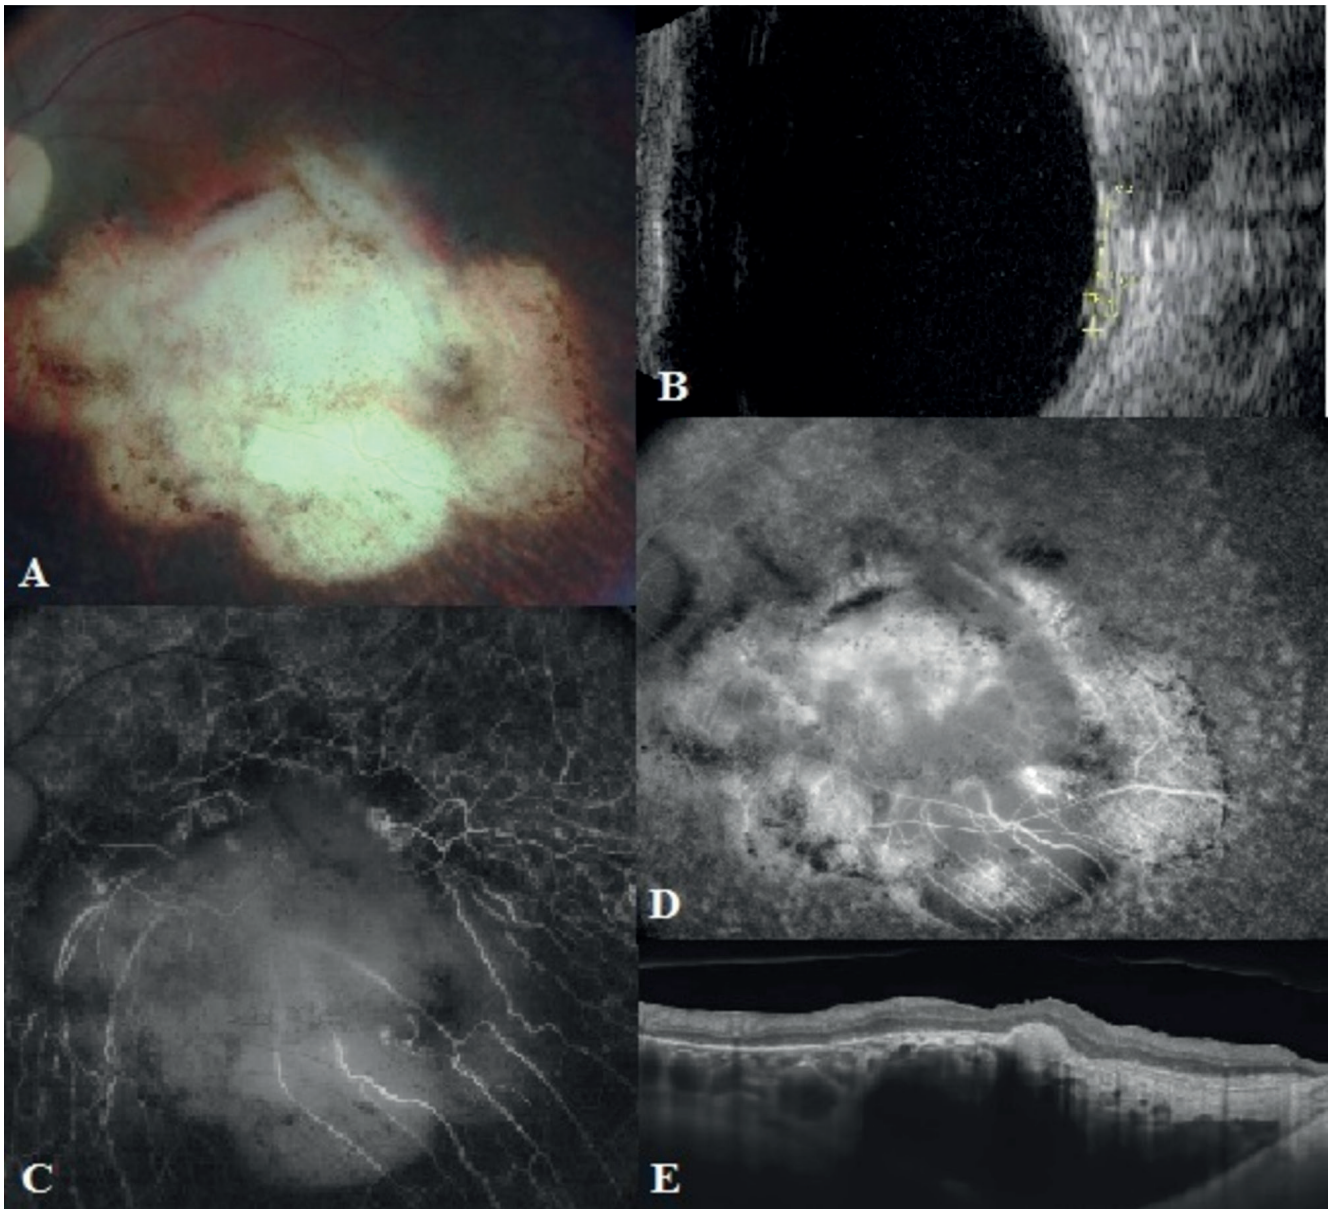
At Month 12, after subretinal triamcinolone acetate and transpupillary thermotherapy: Fundus photo showed atrophic focus in the posterior pole (A). Ultrasonography showed a regressed circumscribed choroidal hemangioma with complete resolution of the exudative retinal detachment (B). In early (C) and late (D) phases fluorescein angiography revealed hyperfluorescence associated with atrophy of the retinal pigment epithelium. Spectral domain optical coherence demonstrated a decrease in elevation of the Bruch pigment epithelium-membrane complex, complete resorption of intraretinal and subretinal fluid (E)
